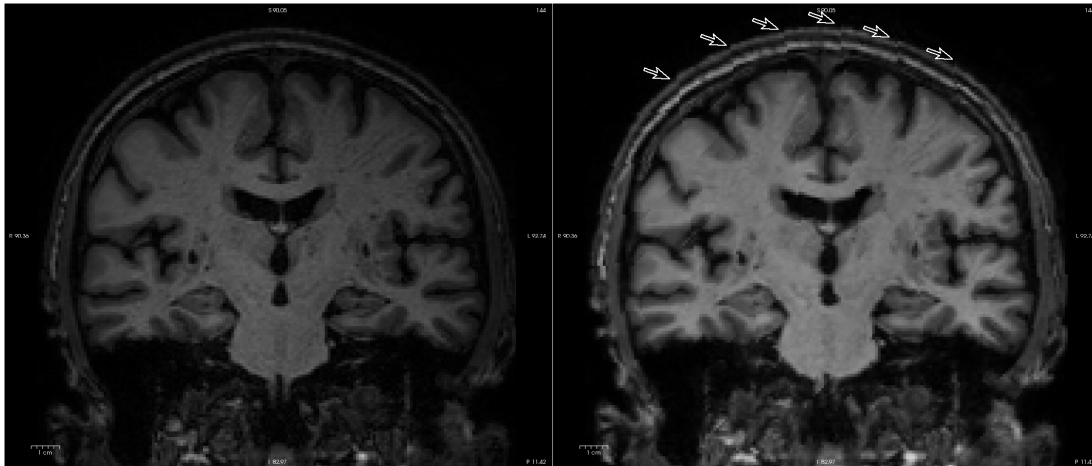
The original MR image '001.mgz' (left) and the processed MR image 'nu.mgz' (right) of one same brain. In 'nu.mgz', there are a few traces of vertical fractures (arrows), which suggests there is tiny deformation in the processed MR image.
